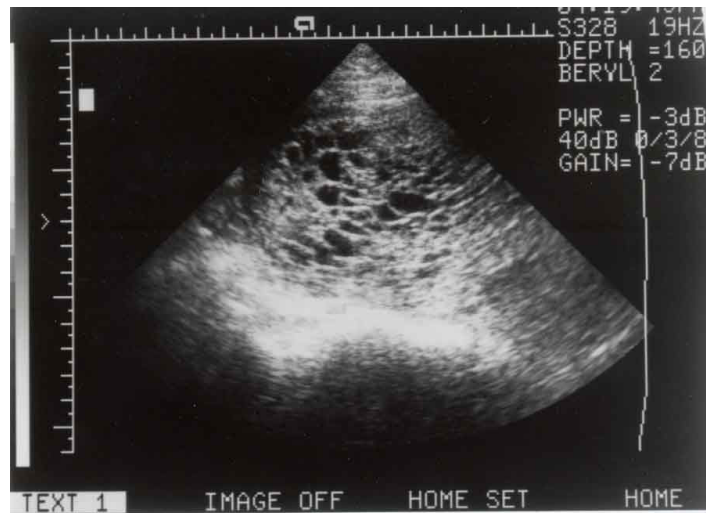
Ultrasound of a complete molar pregnancy showing diffuse vesicular change in the chorionic tissue.
